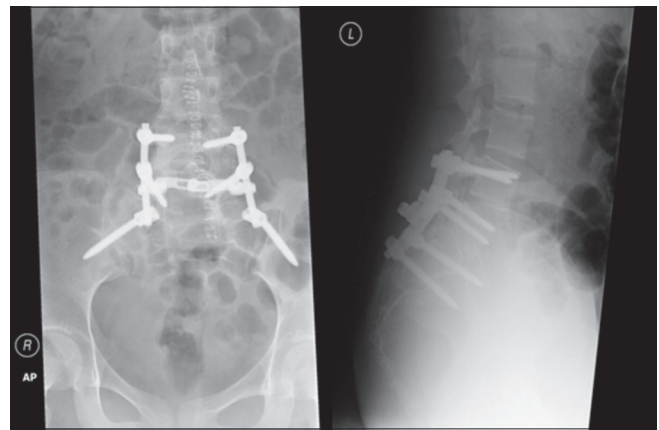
Postoperative radiographs including AP and lateral lumbosacral views
